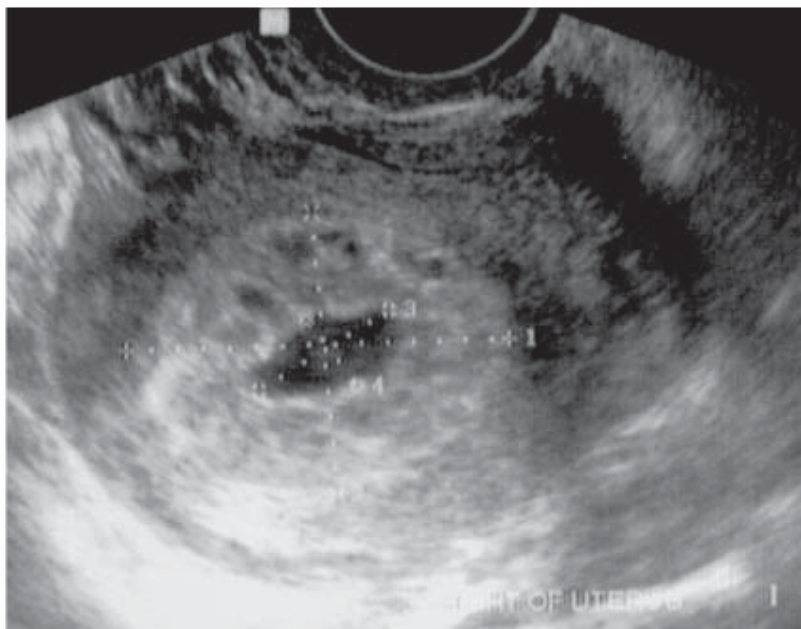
Sonographic image of right cornual pregnancy
